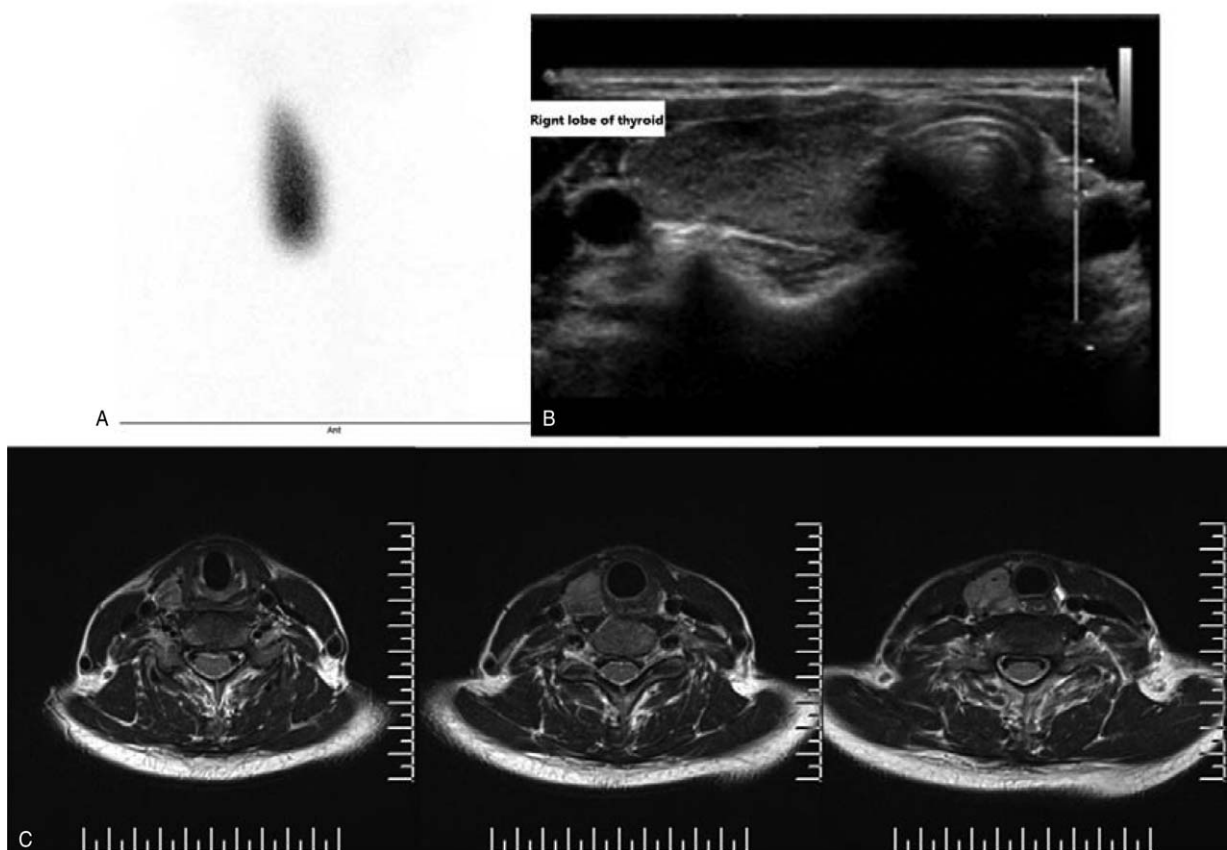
The first technetium thyroid scintigraphy (A) showed the absence of left lobe and isthmus as well as the enlarged right lobe of thyroid with increased tracer uptake with uniform distribution. The ultrasound of thyroid (B) and cervical magnetic resonance imaging (C) both showed the enlarged right lobe of thyroid and agenesis of left lobe and isthmus.
